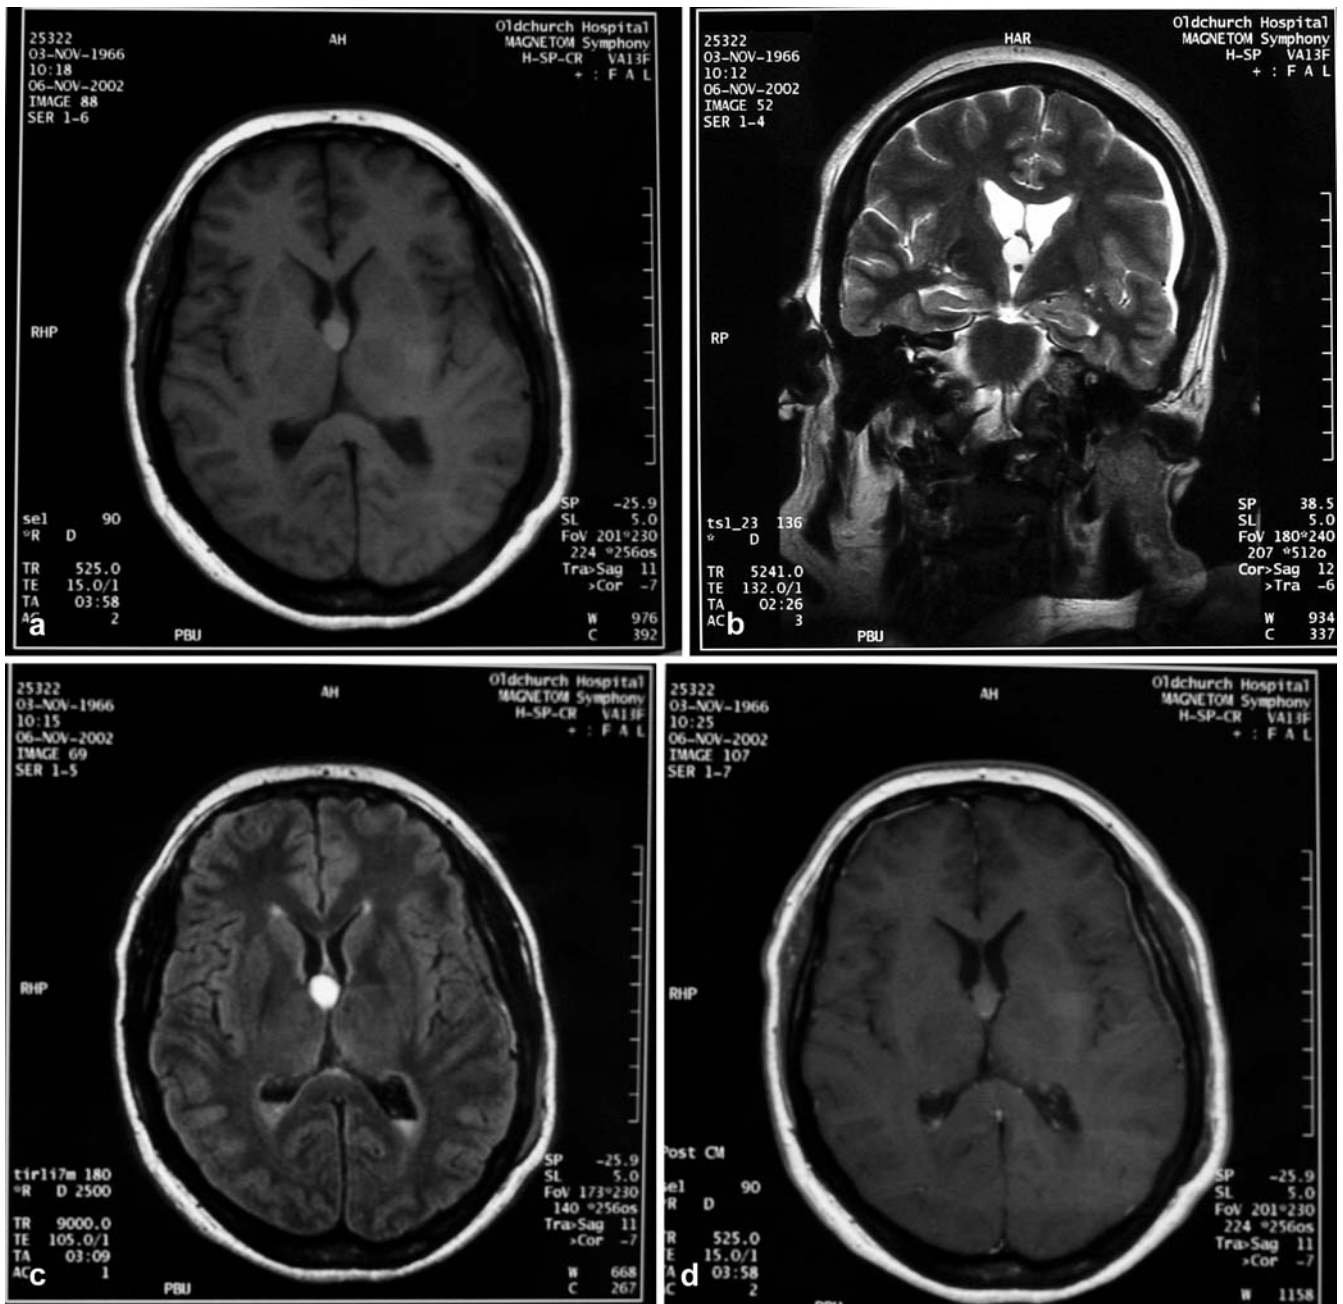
MRI after shunting and immediately prior to cyst resection. a T1-weighted axial image: the cyst centre gives high signal, and the rim more high signal still (especially posteriorly and inferiorly). The ventricular system is now decompressed. b T2-weighted coronal image: the cyst centre gives high signal, the rim low signal. A small left subdural collection is also present. c Fluid-attenuated inversion recovery axial image: the cyst gives markedly high signal throughout, the left subdural collection is isointense. A moderate amount of intraventricular blood is present postshunting. d Contrast-enhanced T1-weighted axial image: no cyst enhancement is seen. Dural enhancement is observed in association with the small subdural collection.
